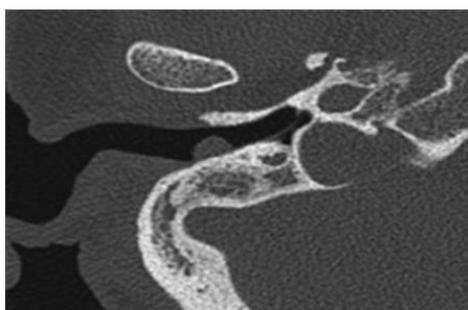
The right temporal axillary CT scan section revealed a small, round polyp in the exposed external auditory canal
